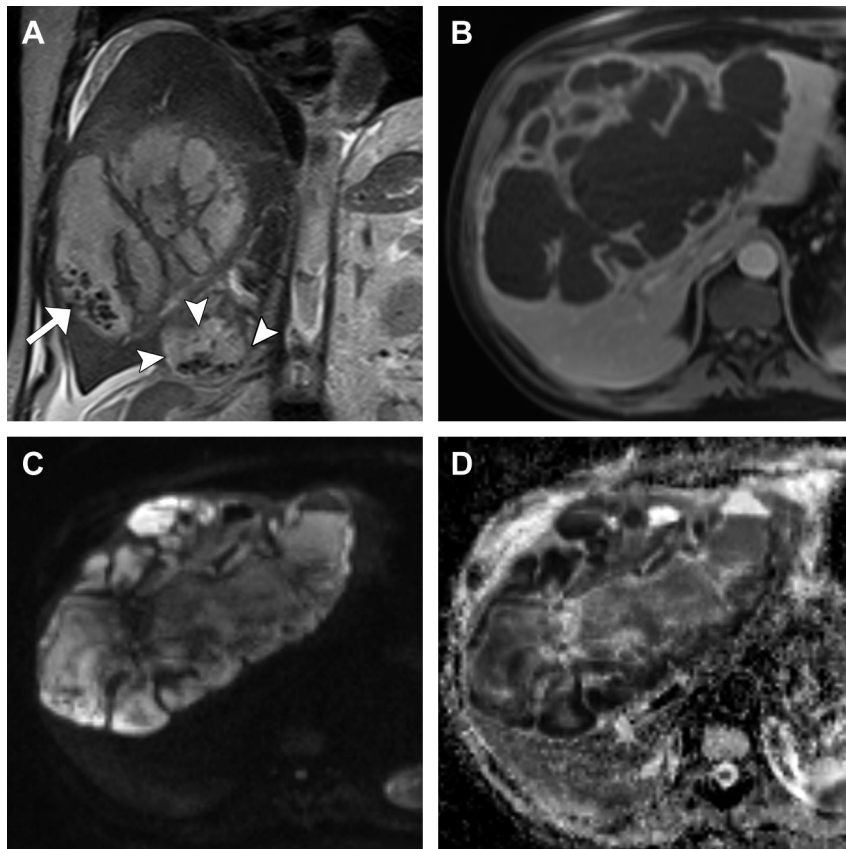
Large pyogenic liver abscess due to intrahepatic rupture of cholecystitis. (A) Coronal T2-weighted image shows a large multiloculated T2 hyperintense hepatic mass containing several tiny spilled gallstones (*arrow*). Gallstones are also seen in the adjacent gallbladder (*arrowheads*). (B) Postcontrast image during equilibrium phase shows diffuse enhancement of its outer wall and several internal septae. (C) The mass exhibits restricted diffusion, with bright signal on the high b-value (800 s/mm²) diffusion-weighted image and low signal on the corresponding ADC map (D).
